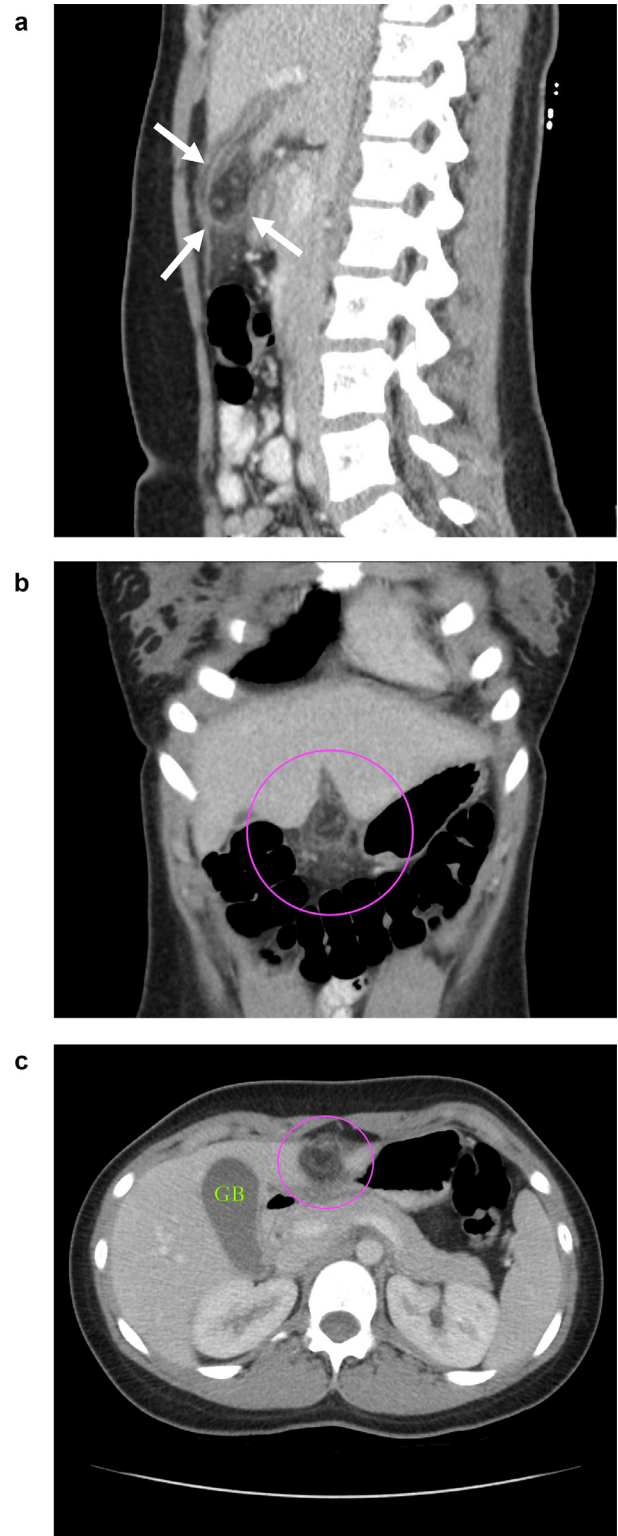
(a) Sagittal CT. Hyperattenuating rim sign and fatty mass with stranding extended into the liver along the course of the falciform ligament (arrows). (b) Coronal CT. (c) Axial CT. CT images of the abdomen and pelvis with IV and oral contrast. Coronal CT (b), and axial CT (c), demonstrate on oval fatty mass with a thin hyperdense rim along the course of the falciform ligament (circle). GB = gallbladder.
